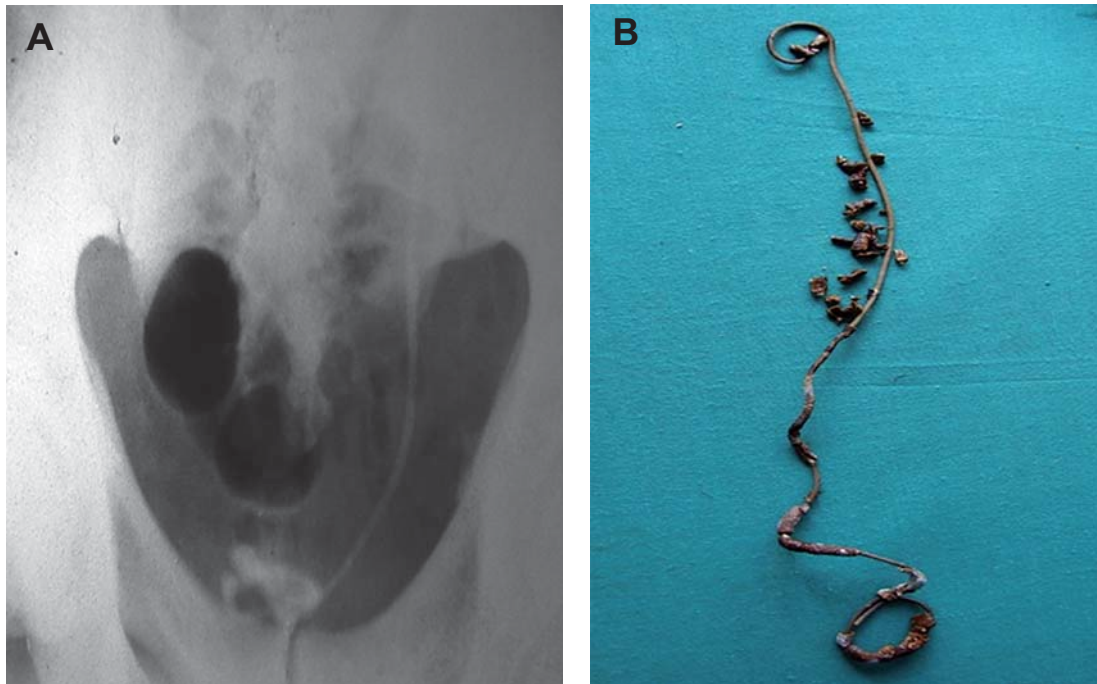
A) Plain-film radiography of a 54 yr old male showing encrusted stent with calculus formation at the lower part and bladder coil of the stent. B) Retrieved stent showing extensive encrustation and stone formation.
